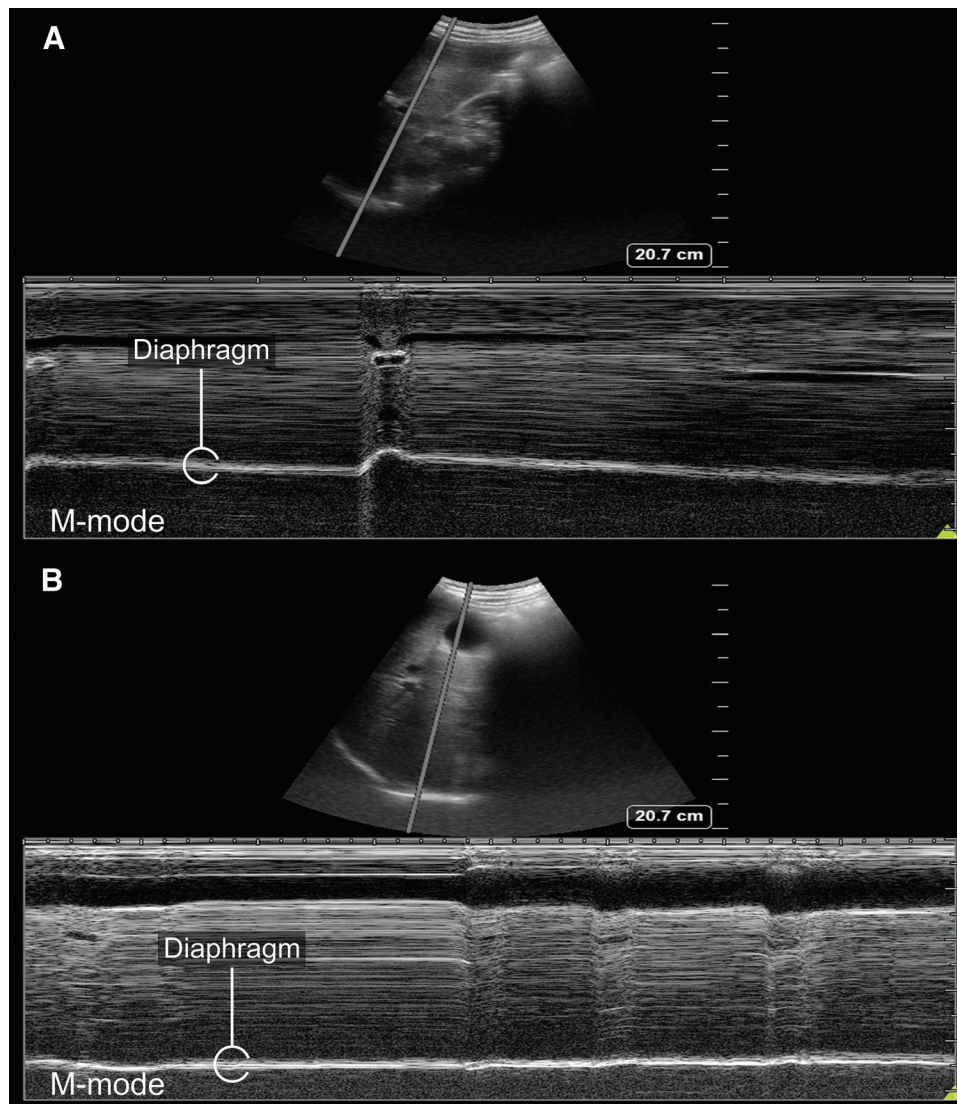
Curved array transducer ultrasound image of the right diaphragm using the liver as an acoustic window in two-dimensional B-mode and M-mode. (A) Preblock sniff test assessment for phrenic nerve palsy. The diaphragm (white circle) is seen to move caudally, toward the probe, in M-mode. (B) Postblock sniff test assessment for phrenic nerve palsy. There is no movement of the diaphragm seen in M-mode, indicating phrenic nerve palsy.
